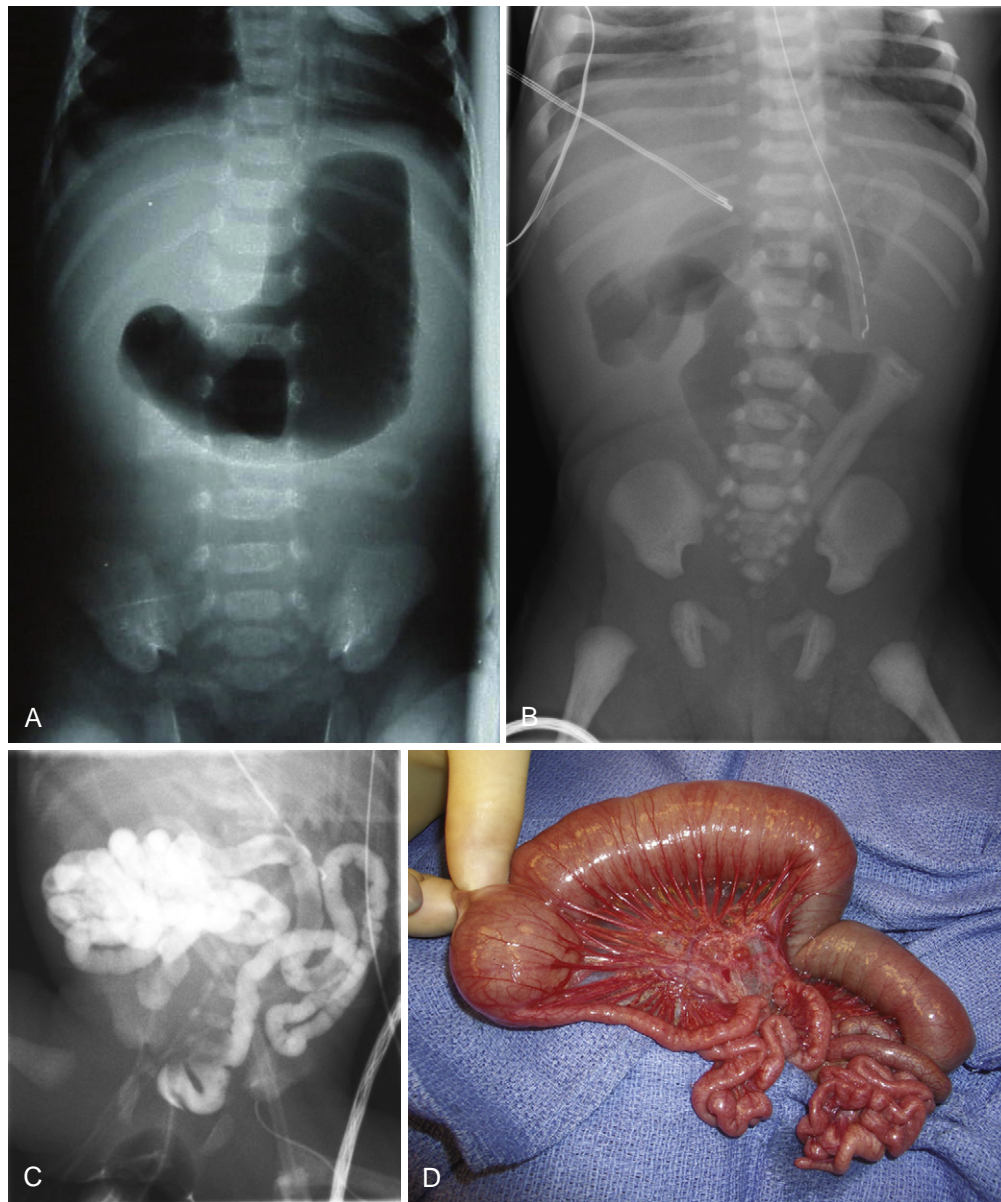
Jejunal atresia. A and B, Plain abdominal radiographs demonstrating a proximal small bowel obstruction. C, Contrast enema revealing an unused colon (microcolon) with incomplete rotation (cecum in the right upper quadrant). Contrast fills multiple decompressed loops of small intestine hinting at a proximal obstruction. D, Type I jejunal atresia seen at laparotomy. The appendix and cecum are seen in the bottom right of the photograph.
